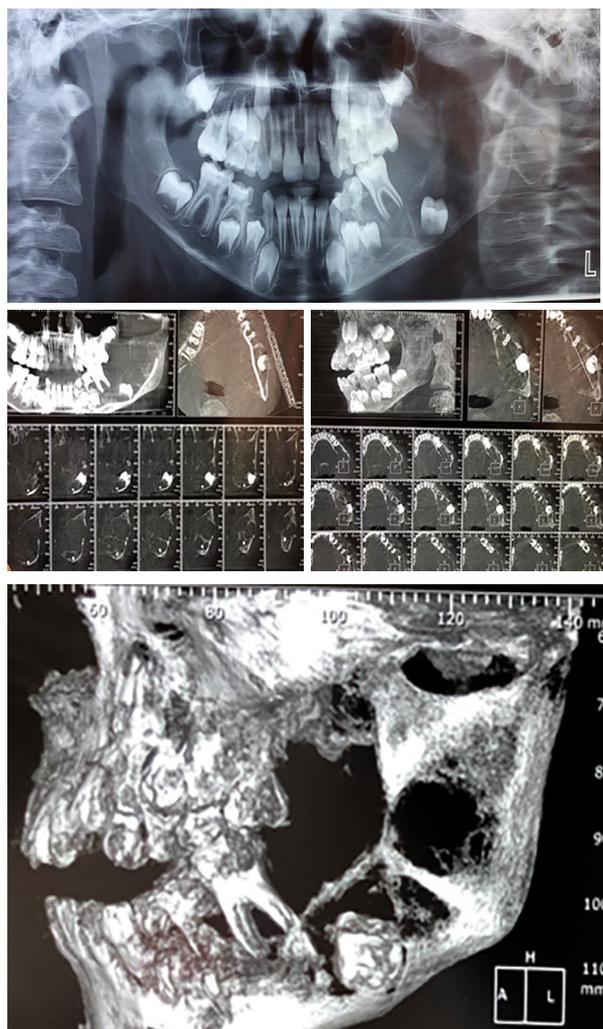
Panoramic radiographic view and CBCT. A multilocular radiolucent lesion with a wispy septum in the left posterior mandible extending from the second primary molar of left side of the mandible to the sigmoid notch, displacing the bud of the permanent second left mandibular molar.
